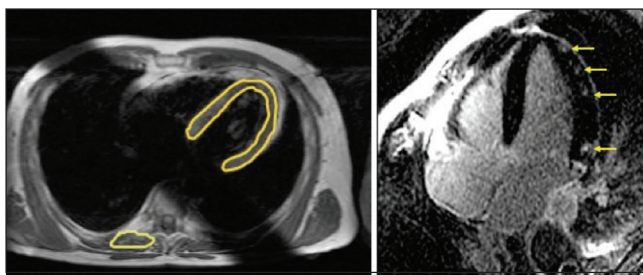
A patient with myocarditis. The quantitative measurements of signal intensities in the myocardium normalized to skeletal muscle using a T1-weighted spin-echo sequence, before and after application of gadolinium contrast, allow for identification of patients with inflammatory myocardial disease (left image). In patients with acute severe myocarditis, patchy foci of delayed enhancement can be visualized, corresponding to foci of acute myocardial necrosis (right image, arrows)
